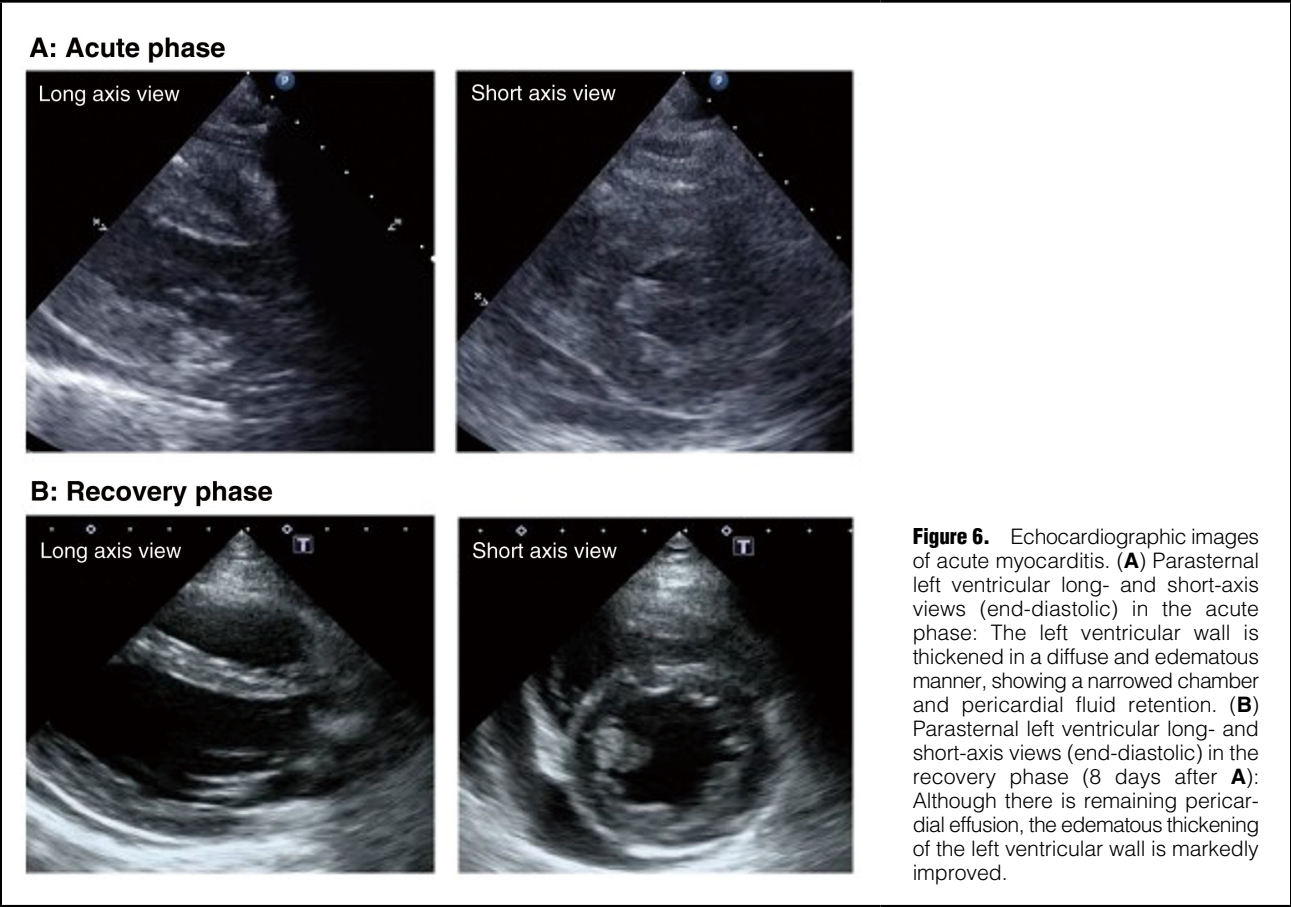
Echocardiographic images of acute myocarditis. (A) Parasternal left ventricular long- and short-axis views (end-diastolic) in the acute phase: The left ventricular wall is thickened in a diffuse and edematous manner, showing a narrowed chamber and pericardial fluid retention. (B) Parasternal left ventricular long- and short-axis views (end-diastolic) in the recovery phase (8 days after A): Although there is remaining pericardial effusion, the edematous thickening of the left ventricular wall is markedly improved.
